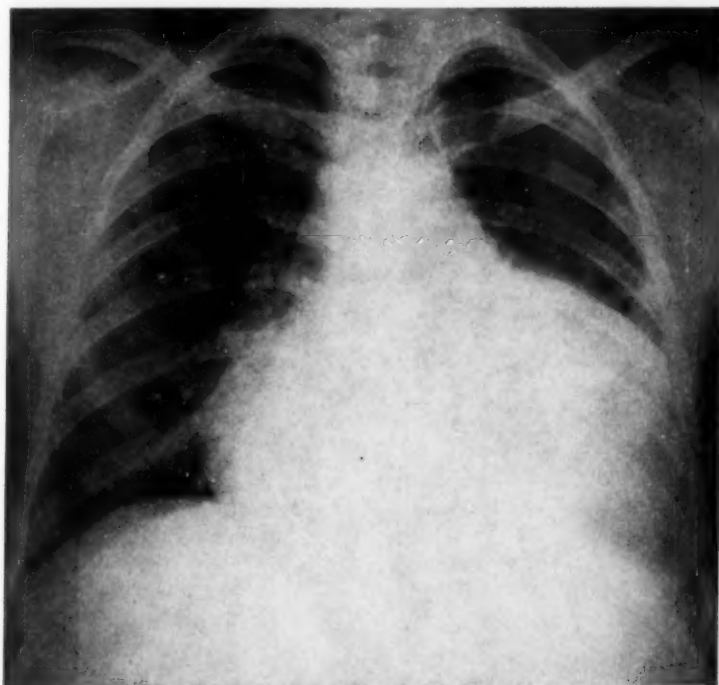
Chest x-ray showing a massive pericardial effusion.
